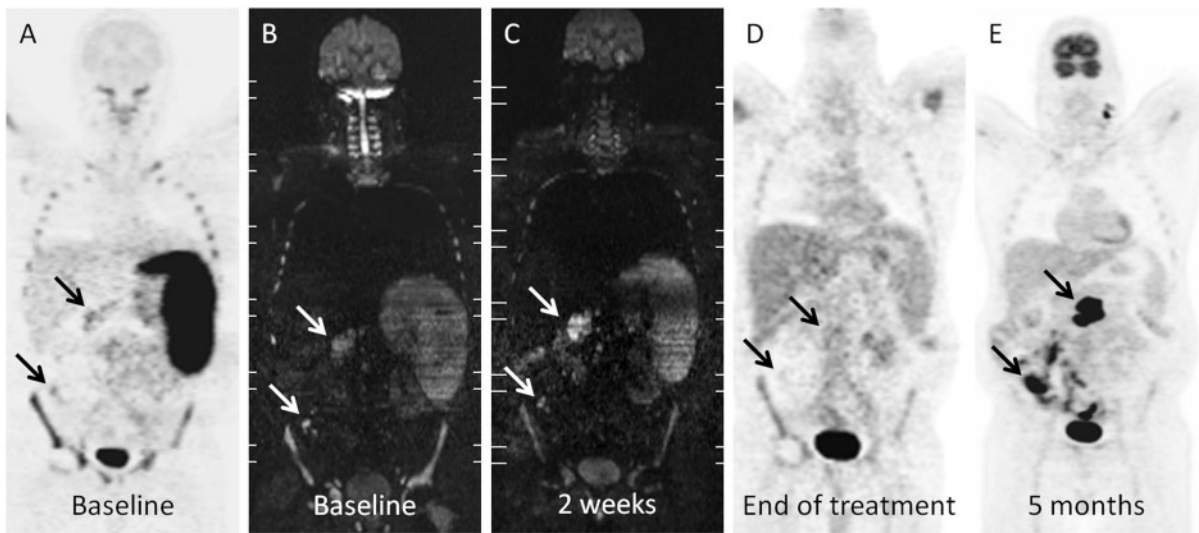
(A) Baseline FDG-PET and (B) MPR coronal reformatted WB DWI b1000 images show a patient with stage IV NHL with tumoural involvement of mesenteric adenopathies (arrows), diffuse skeletal involvement and in the spleen. (C) MPR coronal reformatted WB DWI b1000 images 2 weeks during treatment show unchanged SI in the mesenteric adenopathies (arrows) with an ADC ratio below the threshold of 25%. (D) FDG-PET at the end of treatment shows faint uptake in the largest upper abdominal mesenteric deposit and no uptake in the smallest deposit in the right lower abdomen (arrows). (E) FDG-PET 5 months after end of treatment shows tumour relapse at the site of mesenteric adenopathies (arrows) and in the left upper neck lymph nodes.
